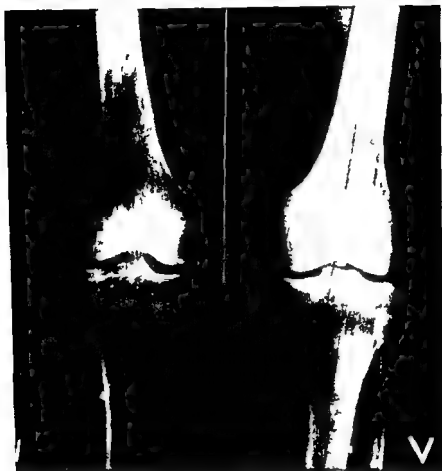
Radiograph of the knee—same patient as in Figure 2
